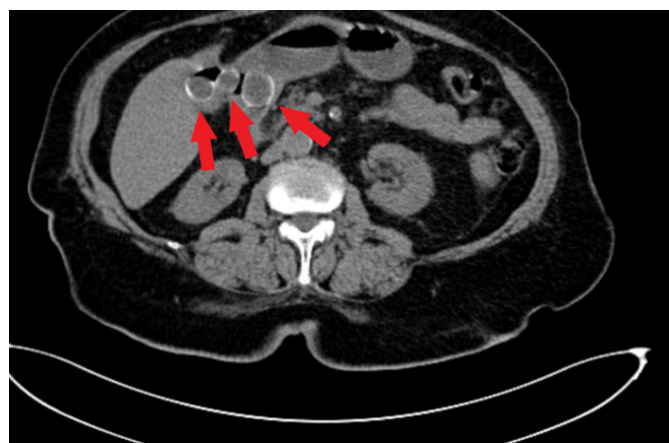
Abdominal contrast enhanced CT (arrows pointing towards migrated gallstones, coronary view)
